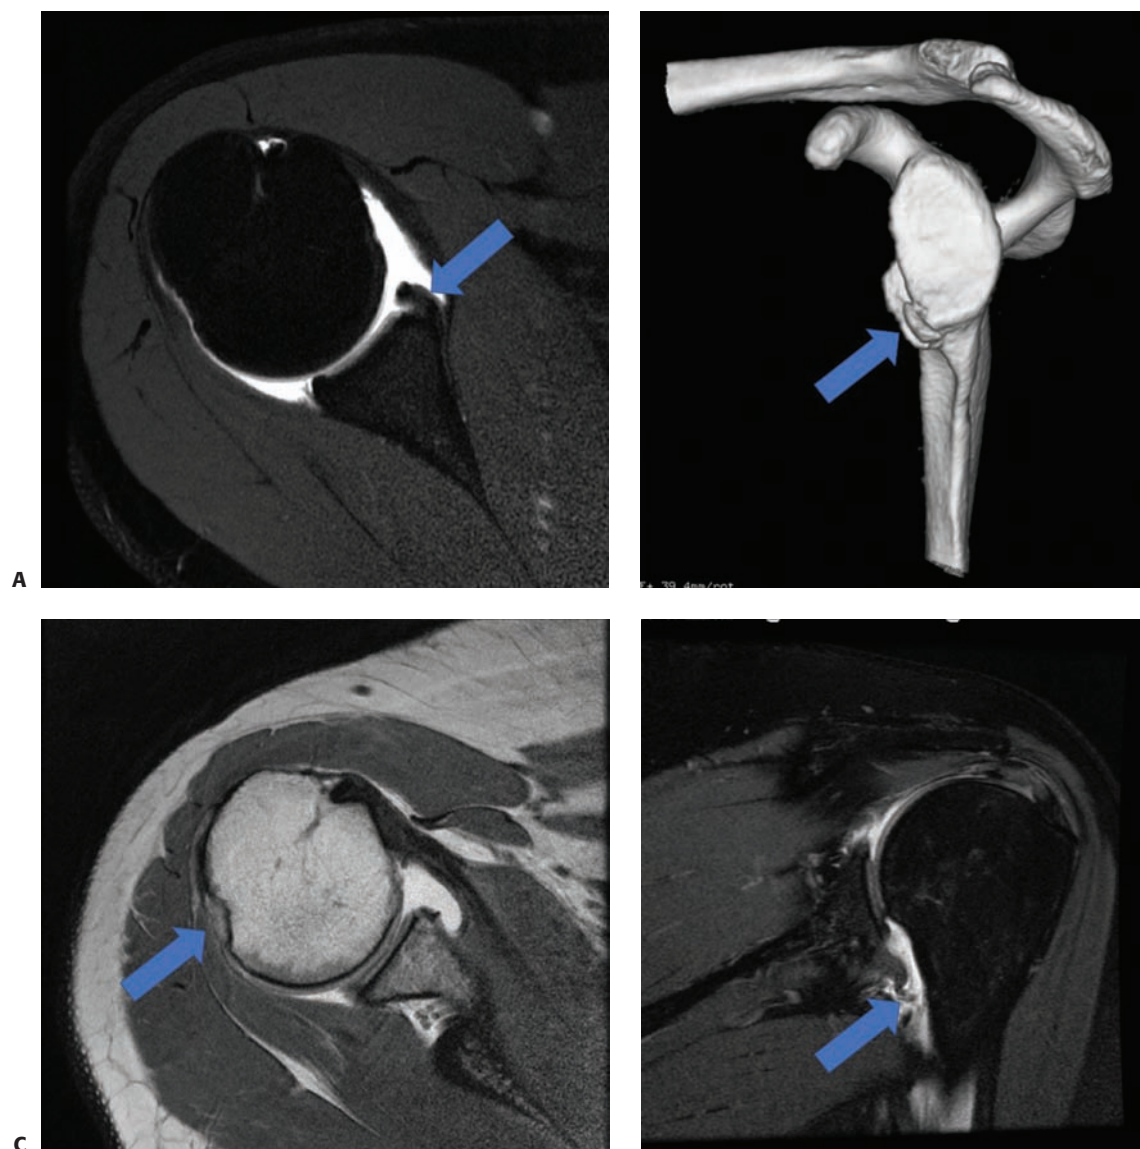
A: Axial T2-weighted magnetic resonance image with arthrogram (MRA) demonstrates anterior inferior labral tear or “Bankart” lesion. B: CT image with 3D reconstruction of the glenoid shows “bony Bankart” lesion on the anterior inferior glenoid. C: Axial T1-weighted MRA image shows “Hill–Sachs” lesion on the posterior humeral head. D: Coronal T2 MRA image shows humeral avulsion of glenohumeral ligament (HAGL) lesion.
